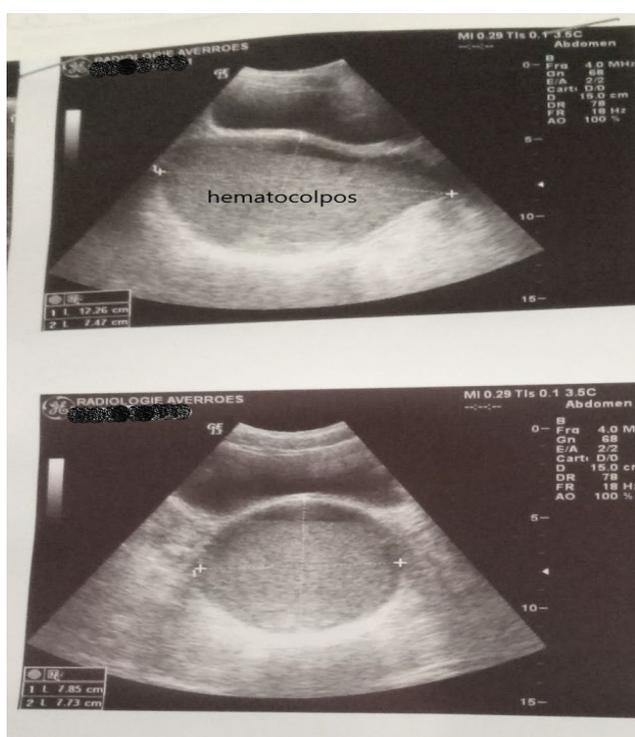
An ultrasound scan showing a large retrovesical collection in favor of a hematocolpos.
